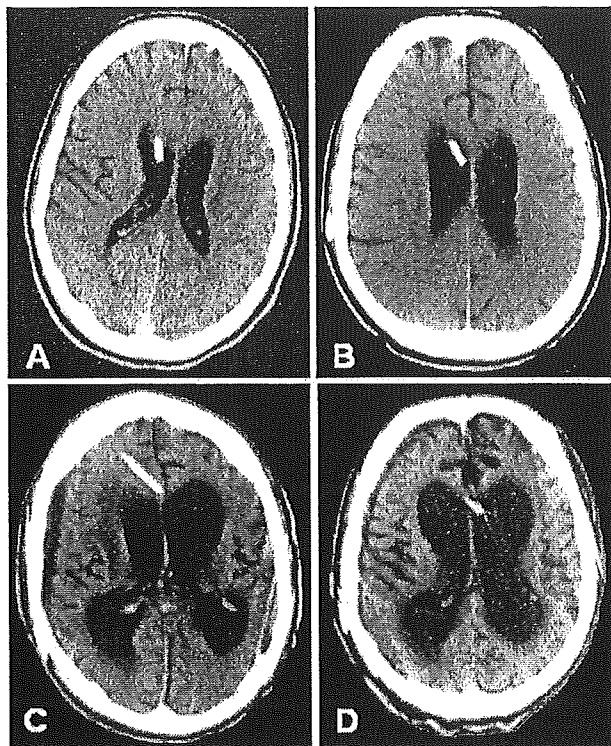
(A) Non-enhanced CT scan on day 6 after start of cerebroventricular PPS infusion. (B) Non-enhanced CT scan 3 months after start of PPS infusion. Note the slightly enlarged lateral ventricles compared to baseline (A). (C) Non-enhanced CT scan 1-year after start of PPS infusion. (D) Non-enhanced CT scan 15 months after start of PPS infusion. Note progressing cortical and subcortical atrophy with enlargement of the ventricular system on scans C and D.
